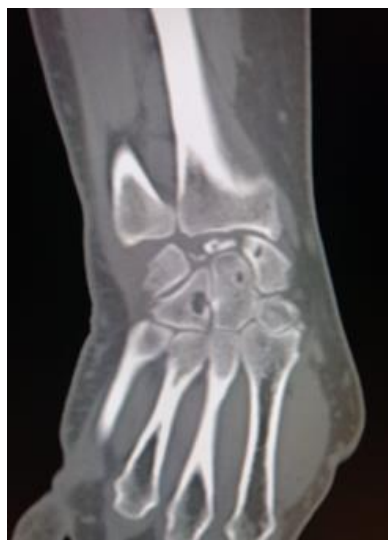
Radiographs showing inhomogeneous condensations of the lunate bone [13]
